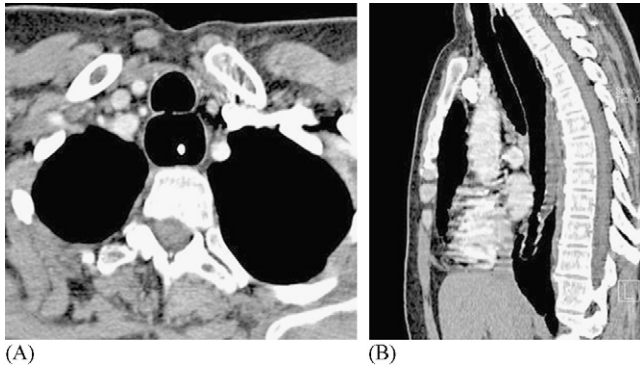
(A) Sagittal section of a CT scan revealing a congenital tracheo-oesophageal fistula. (B) Transverse section of a CT scan revealing a congenital tracheo-oesophageal fistula.
